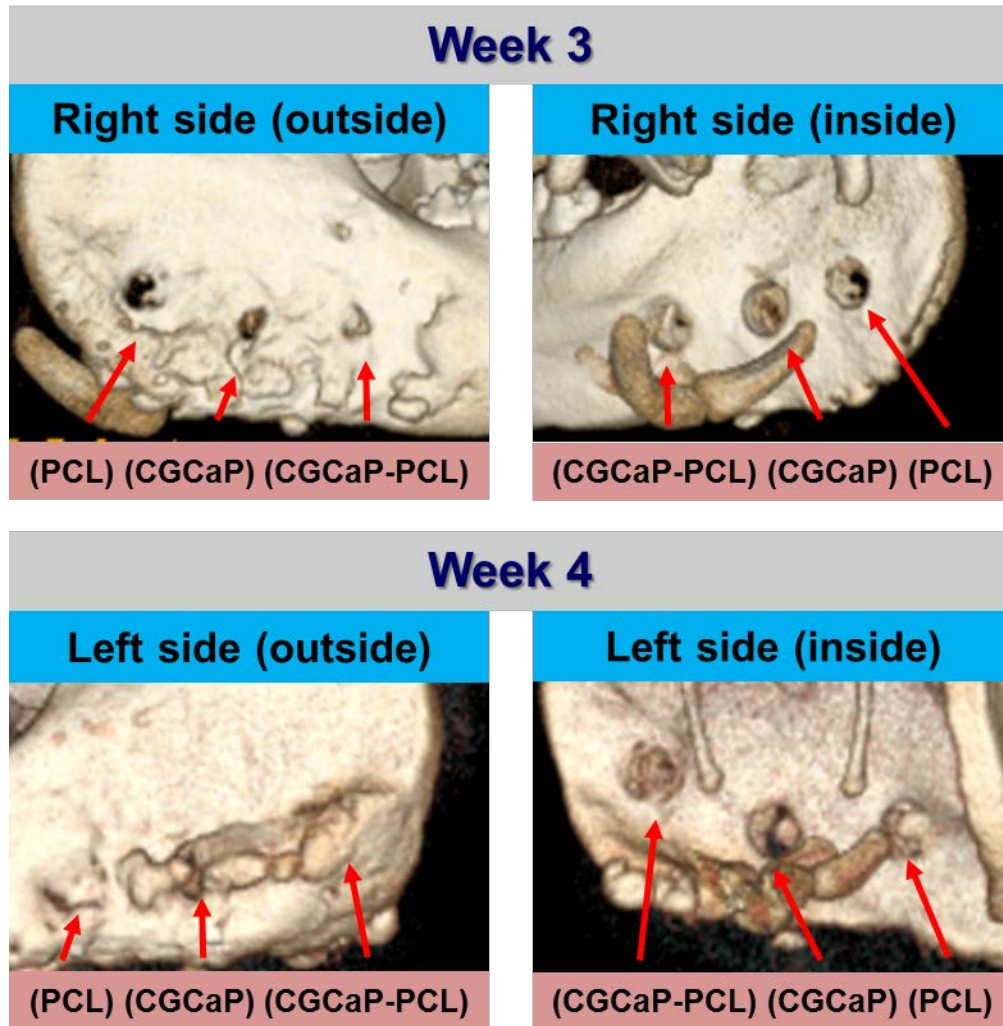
Example of micro-computed tomography during *in vivo* culture.
